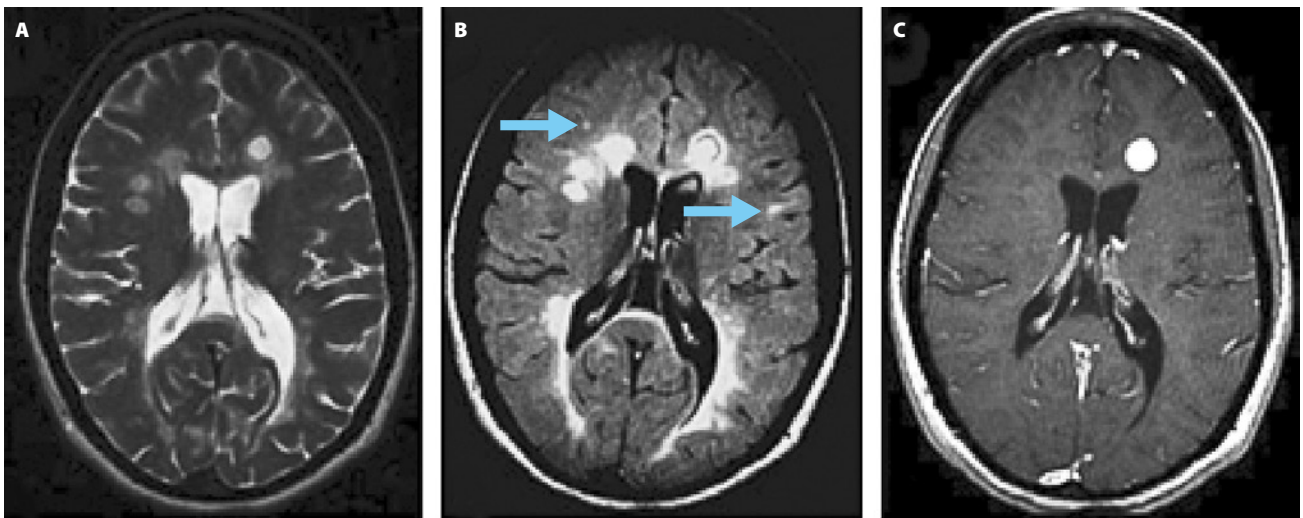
Axial magnetic resonance (MR) images of the brain of a 30-year-old woman with relapsing-remitting multiple sclerosis (MS). A. T2-weighted MR image. B. FLAIR (fluid-attenuated inversion recovery) image. C. Contrast-enhanced T1-weighted image. The lesions on FLAIR usually are prominent and several small lesions are depicted only on FLAIR (arrows). Reprinted with permission from Ge Y. Multiple sclerosis: the role of MR imaging. AJNR Am J Neuroradiol. 2006;27(6):1165-1176.
